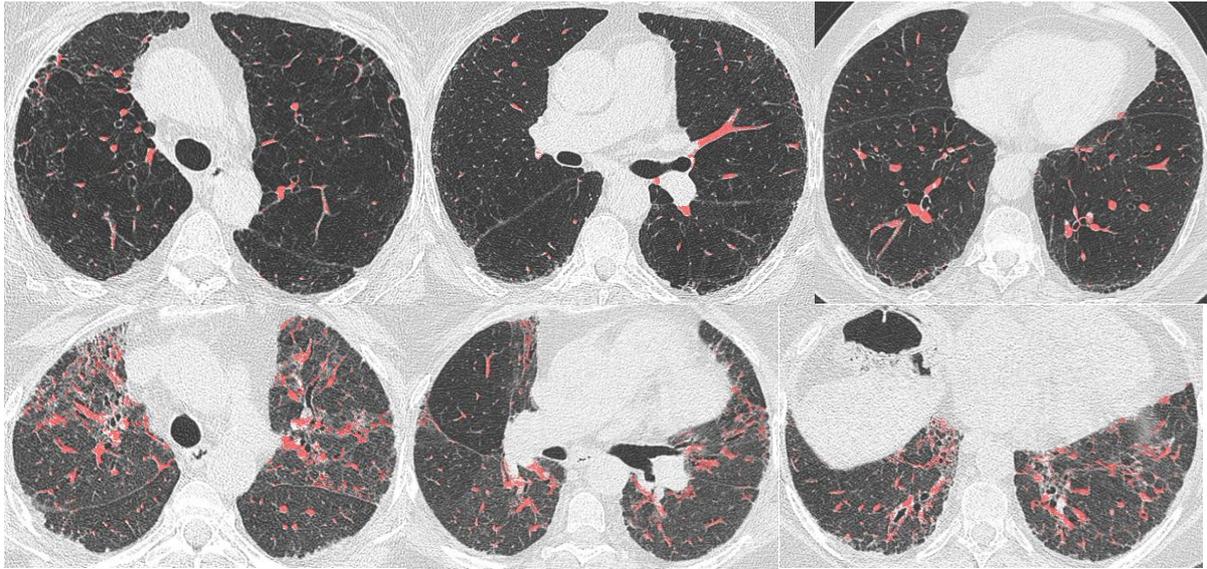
Axial CT image colour maps demonstrating CALIPER-derived vessel-related structures labelled in red. Vessel-related structures represent pulmonary arteries and veins (excluding hilar vessels) and connected tubular structures, the latter primarily reflecting adjoining regions of fibrosis. Figure 2a-c represents axial sections in a 71-year-old female 30-pack-year ex-smoker with upper lobe emphysema and fibrosis visible in the lower lobes (VRS=2.1%). Figure 2d-f represents axial sections in a 62-year-old female never-smoker with upper lobe predominant fibrosis (VRS=7.0%). Non-vascular regions captures in the VRS signal are visible in the upper lobes (d) and adjacent to the right hemidiaphragm (f).
